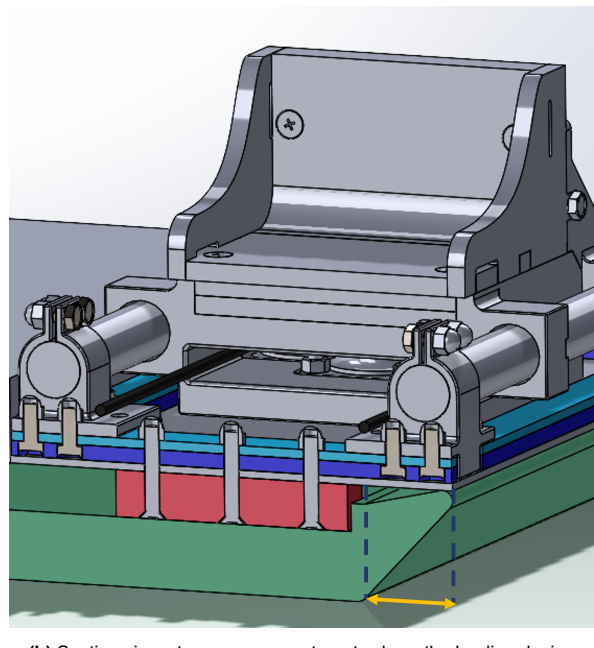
Protruding bars at the bottom of the base plate secure the 'MRI knee loading device' in position.
